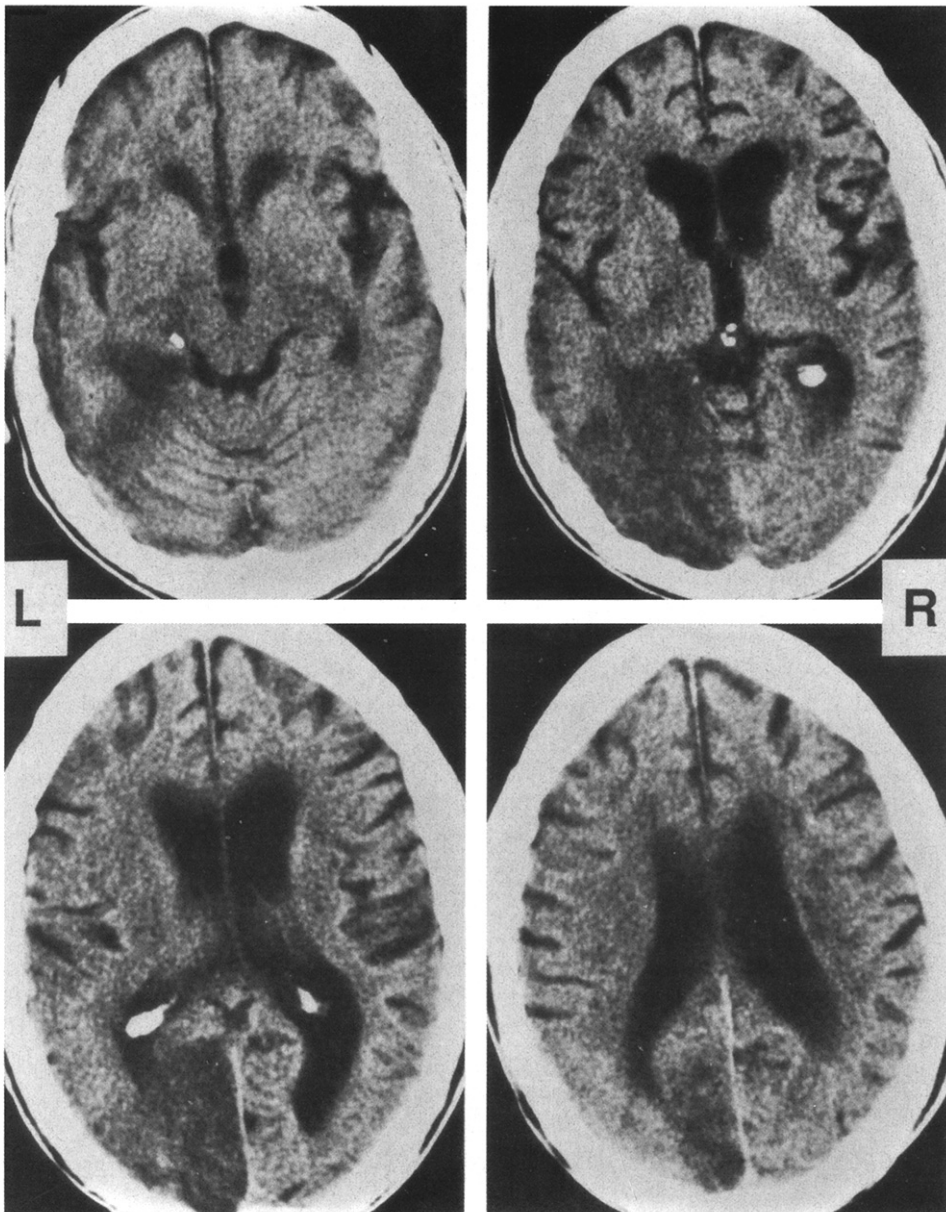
CT scan of the head, 7 days post onset, shows an infarct of the infero-medial portions of the left occipital and temporal lobe. The lingual, fusiform and posterior parahippocampal gyri appear mostly destroyed, the lower-most part of the cuneus is partially damaged.
